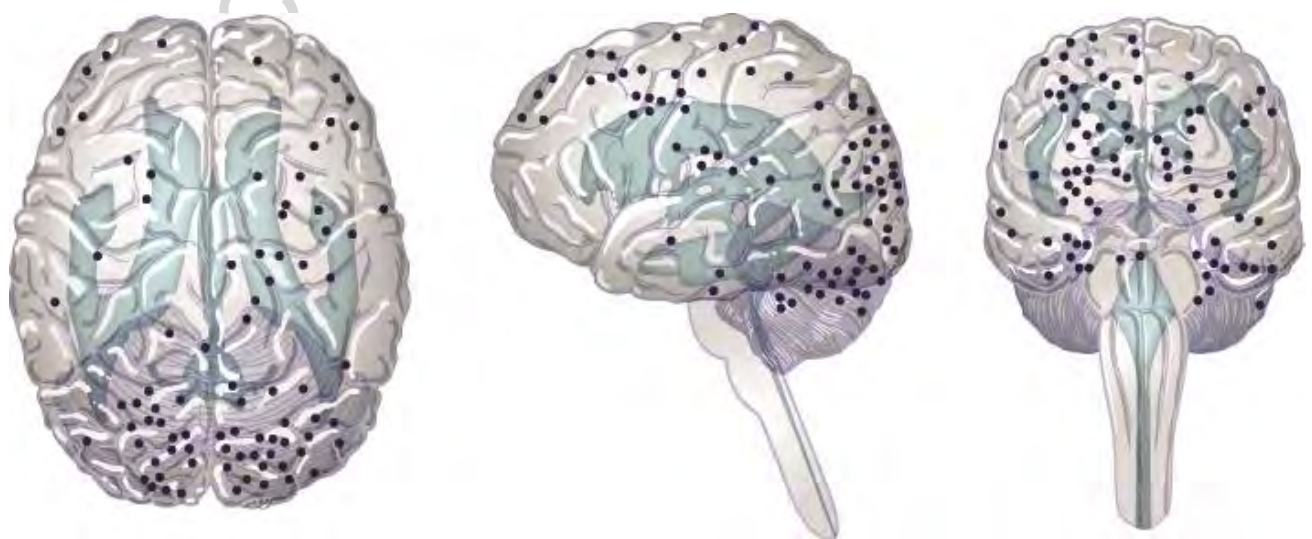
Anatomical distribution of MRI-defined cerebral infarctions in three-dimensional views of the brain:
